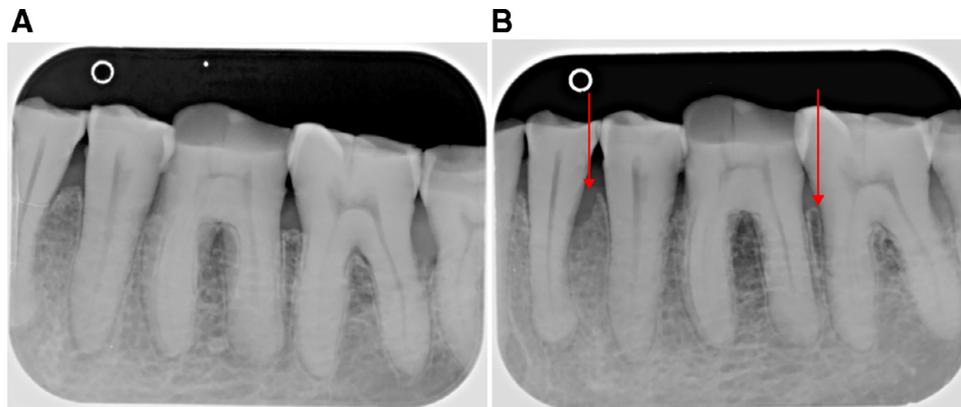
Intraoral radiographs of the same site predefect (A) and postdefect (B). In the postdefect radiograph, the left red arrow points to notable bone loss distal to tooth #21. The right red arrow points to bone loss mesial to tooth #18, which remains obscured by anatomic superimposition and greater buccolingual bone thickness.
